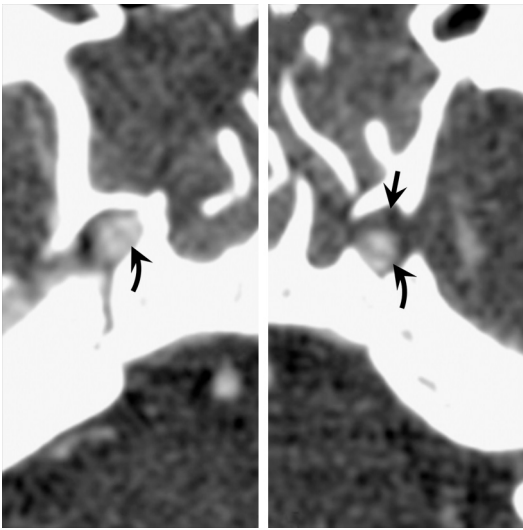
Subtle bilateral ICA dissections with intimal flaps. The CTA image reveals bilateral ICA dissections with subtle intraluminal intimal flaps (*curved arrows*) consistent with a Denver grade 2 injury. Additionally seen is extraluminal hematoma (*arrow*) that does not compress the arterial lumen.
